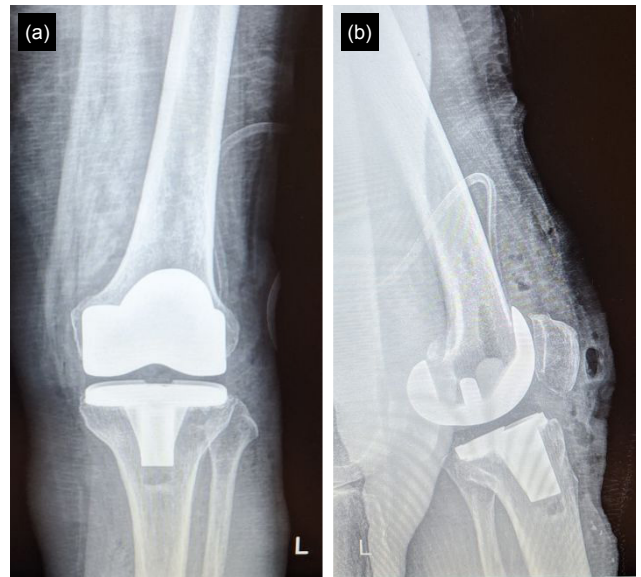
Postoperative anteroposterior (a) and lateral (b) knee radiograph. The operation was concluded uneventfully
